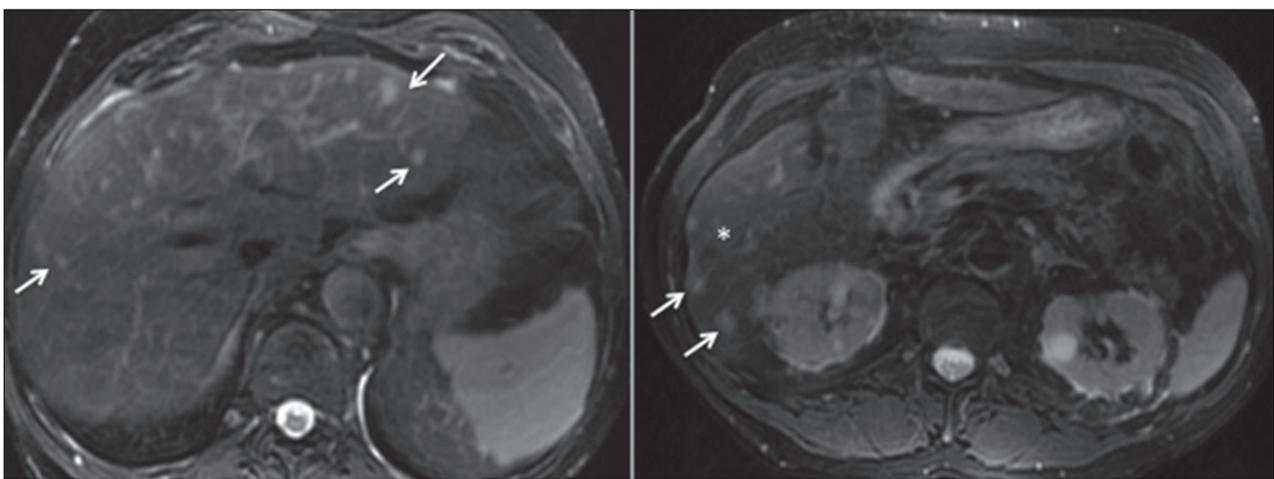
Axial T2 weighted Liver MRI images obtained six months after the end of DAA treatment. Numerous hyper-intense lesions have appeared throughout liver parenchyma (arrows). The area previously ablated (*) does not show radiological signs of tumor persistence.
